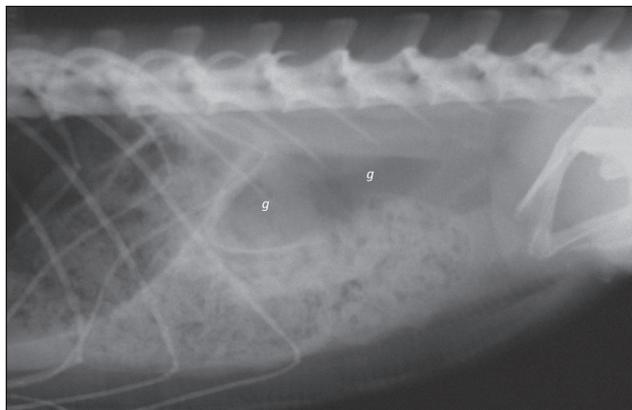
Lateral abdominal radiograph of a green iguana (*Iguana iguana*) with foamy gastrointestinal content and gas accumulation (g) ventrocranial to the kidneys. The foamy intestinal content was believed to be normal ingesta, but it most likely represents the surgically removed foreign body.
